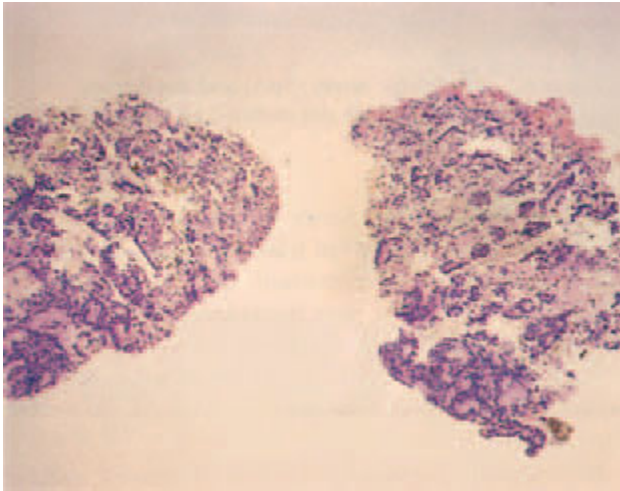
Fine-needle aspiration under ultrasound guidance yielded a clump of HCC cells.
